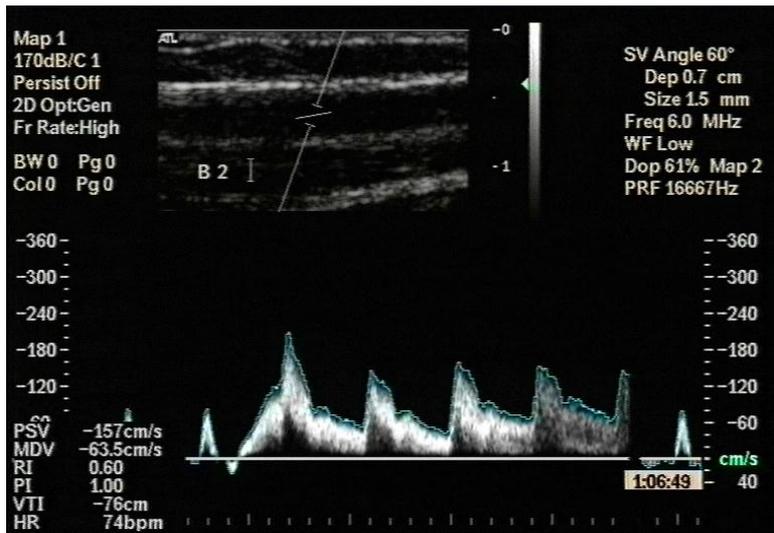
Doppler waveform image at time of cuff release. Note reduced flow at left of picture and immediate increase in flow that occurs at time of cuff release.
